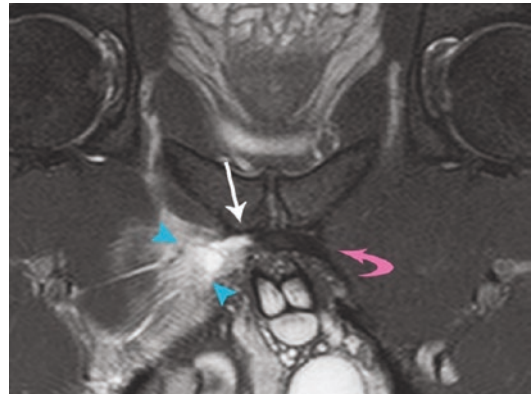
A distal rectus abdominis tear or detachment with an adductor longus origin tear is one of the most frequently encountered lesions on MRI. The aponeurosis has been avulsed from the pubic tubercle (white arrow) with edema extending well into the adductor compartment (blue arrowheads)
